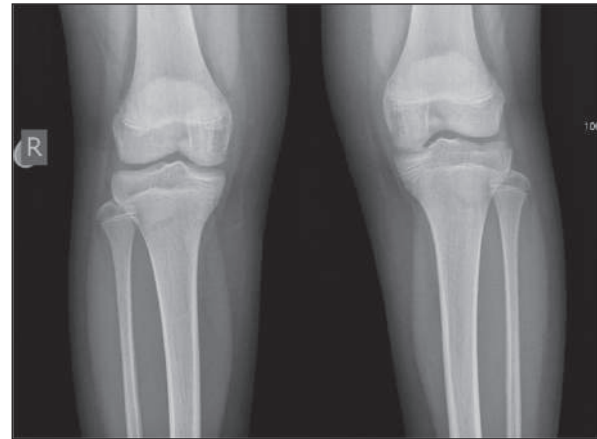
Bilateral knee radiography of a 9-year-and-11-month-old girl diagnosed with idiopathic precocious puberty: growth plates with a tendency to close
